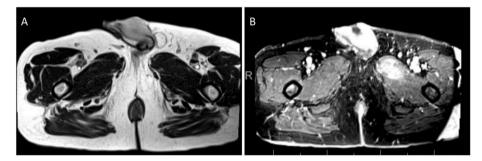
A) MRI Pelvis showing a $3.7 \times 5.7 \times 3.9$ cm moderately T2 hyperintense lesion which involves the left corpus cavernosum in the mid penile shaft; B) Lesion demonstrates enhancement with an area of central necrosis.
